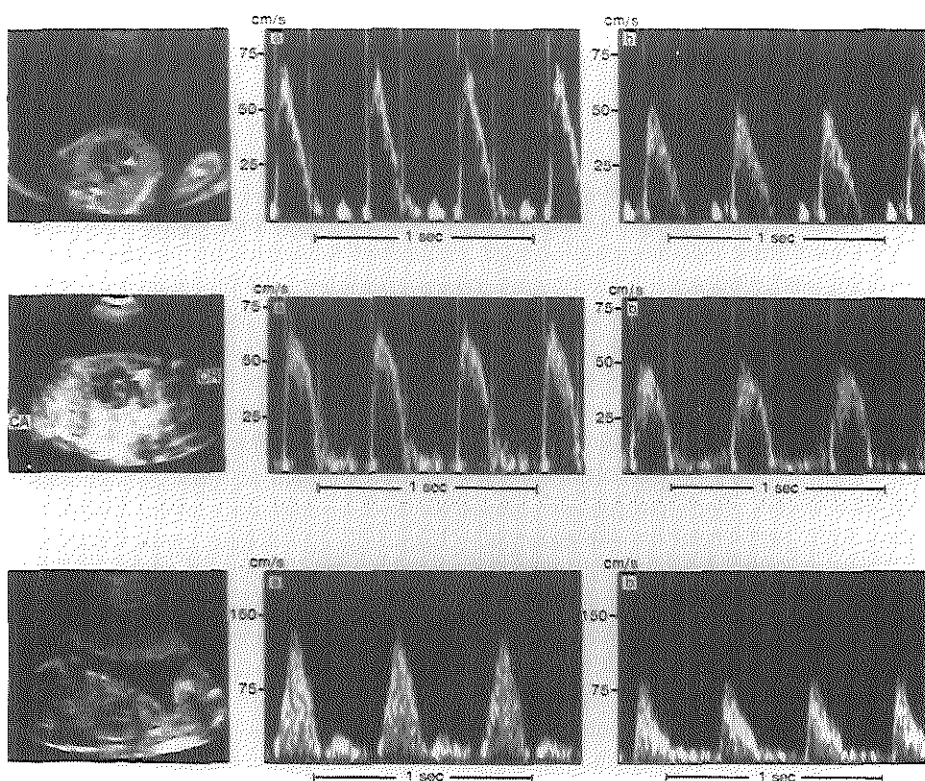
Top panel: Two-dimensional five-chamber view of the human fetal heart with Doppler flow velocity waveform tracings from the ascending aorta (see arrow) during normal pregnancy (a) and intrauterine growth retardation (IUGR) (b). Middle panel: Two-dimensional short axis and pulmonary arterial view of the human fetal heart with Doppler flow velocity waveform tracings from the pulmonary artery (see arrow) during normal pregnancy (a) and IUGR (b). CR, cranial; CA, caudal. Bottom panel: Two-dimensional short axis view of the human fetal heart parallel to the fetal spine with Doppler flow velocity waveform tracings from the ductus arteriosus (see arrow) during normal pregnancy (a) and IUGR (b).
